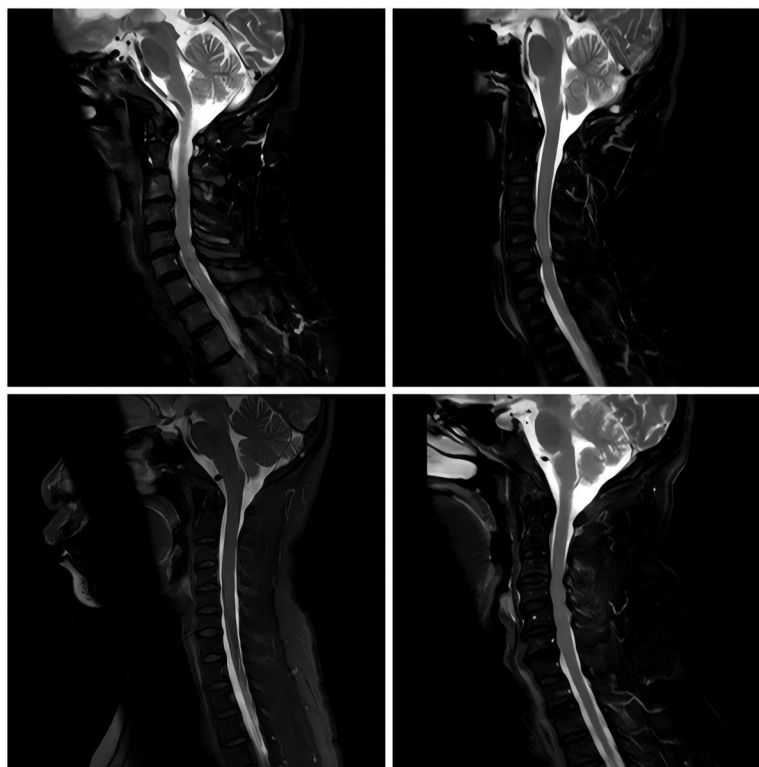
Cervical spine MRI of selected patients. MRI = magnetic resonance imaging.
